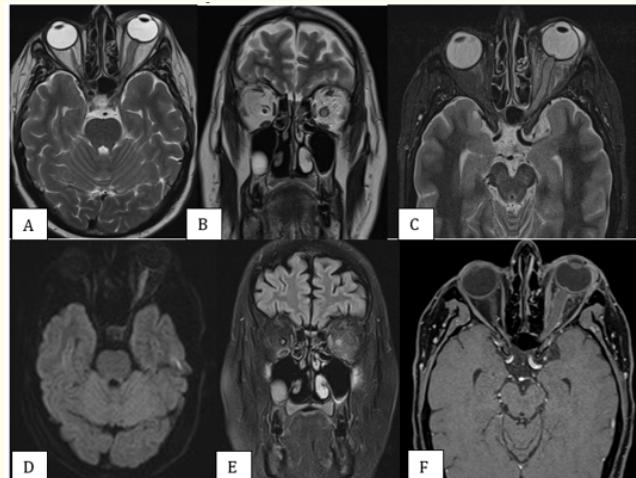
A, B: Axial and coronal slices from the T2 sequence. C: Axial slices from the T2 FS sequence. D: DWI sequence. E: Flair sequence. F: T1 FS with injection. These sequences revealed left optic nerve infiltration and thickening, with T2/FLAIR hyperintensity, moderate diffusion restriction, and linear gadolinium enhancement of the optic nerve sheath. Associated intra-conal fat infiltration and ipsilateral palpebral soft tissue thickening were also seen.
